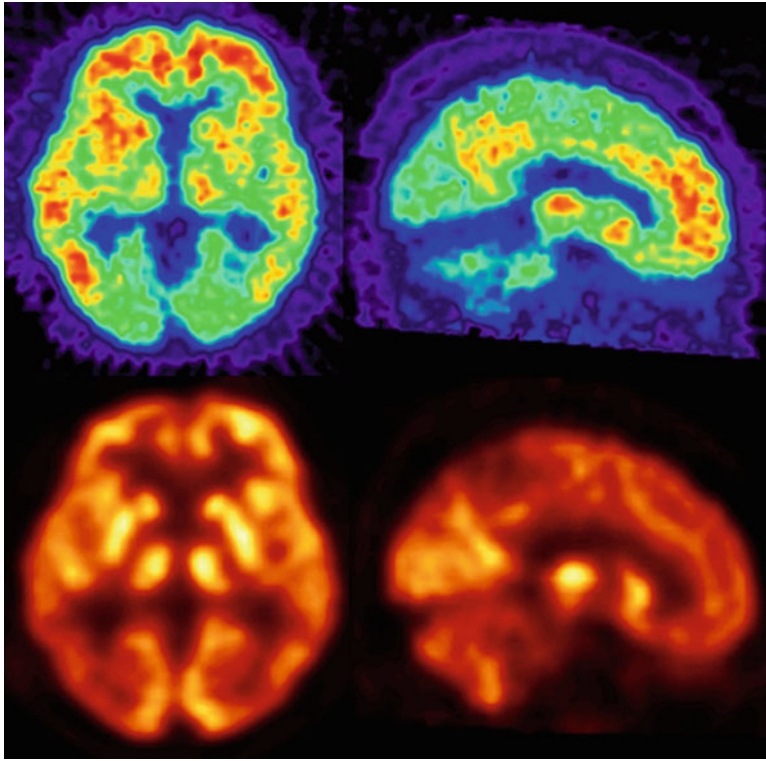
[^{11}C]PIB PET (*upper row*) and ^{18}F -FDG PET images (*lower row*) of AD
